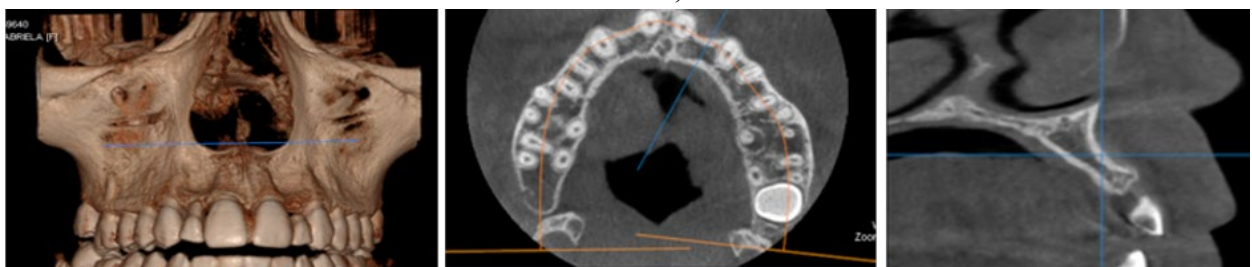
3-dimensional radiography with the conical beam and evaluation of the tissue in the frontal region.
